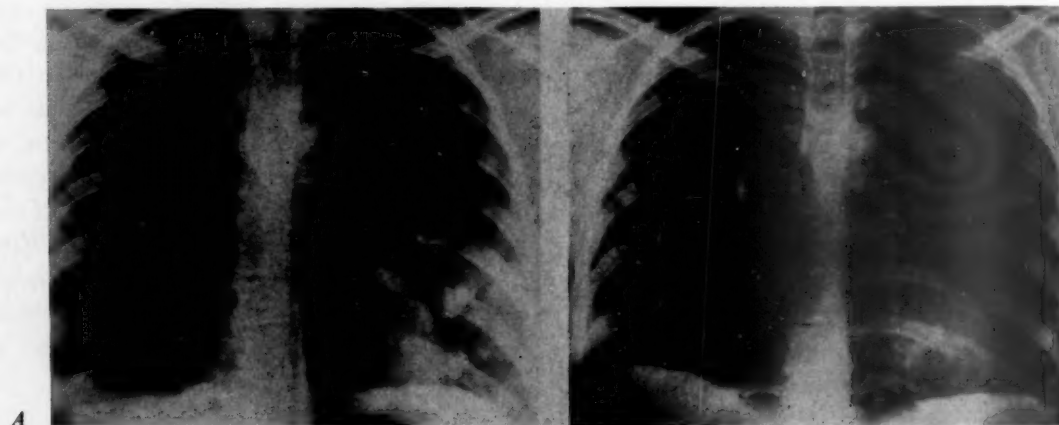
X-rays (A) and gonadotropin titer (B) in patient with choriocarcinoma in incomplete remission since March, 1961, following 6 courses of amethopterin.
